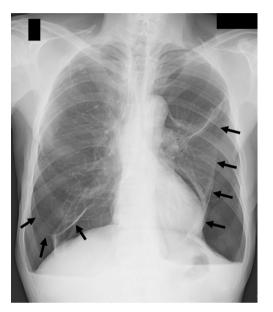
Chest radiograph on admission showing simultaneous bilateral pneumothoraces. Both of the lungs collapsed, as shown by the arrows. The pneumothorax was found to be more severe on the left side compared to the right.
